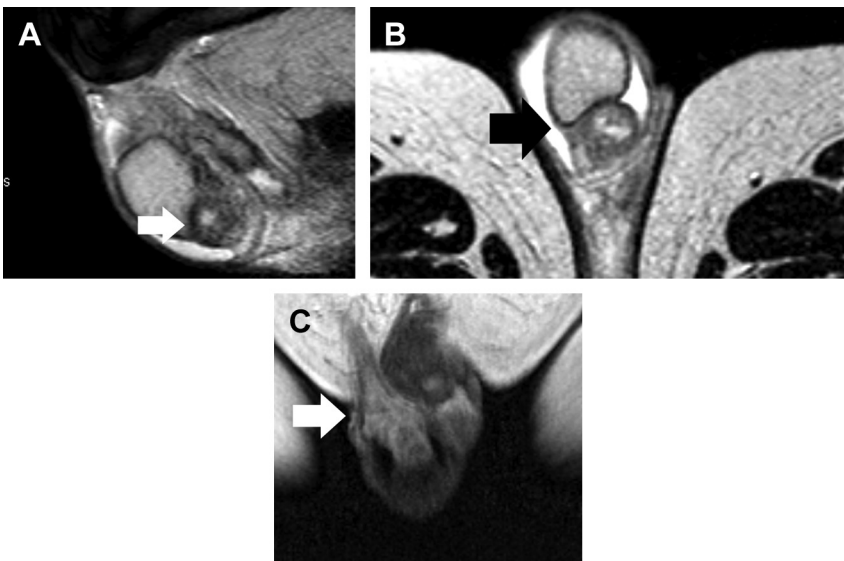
Right epididymitis in a 79-year-old man. (A) Sagittal and (B) transverse T2-weighted images show enlargement and heterogeneity of the right epididymal tail (*arrow*). (C) Coronal DCE depicts heterogeneous enhancement of the right epididymal head (*arrow*). Imaging findings are typical of epididymitis.
